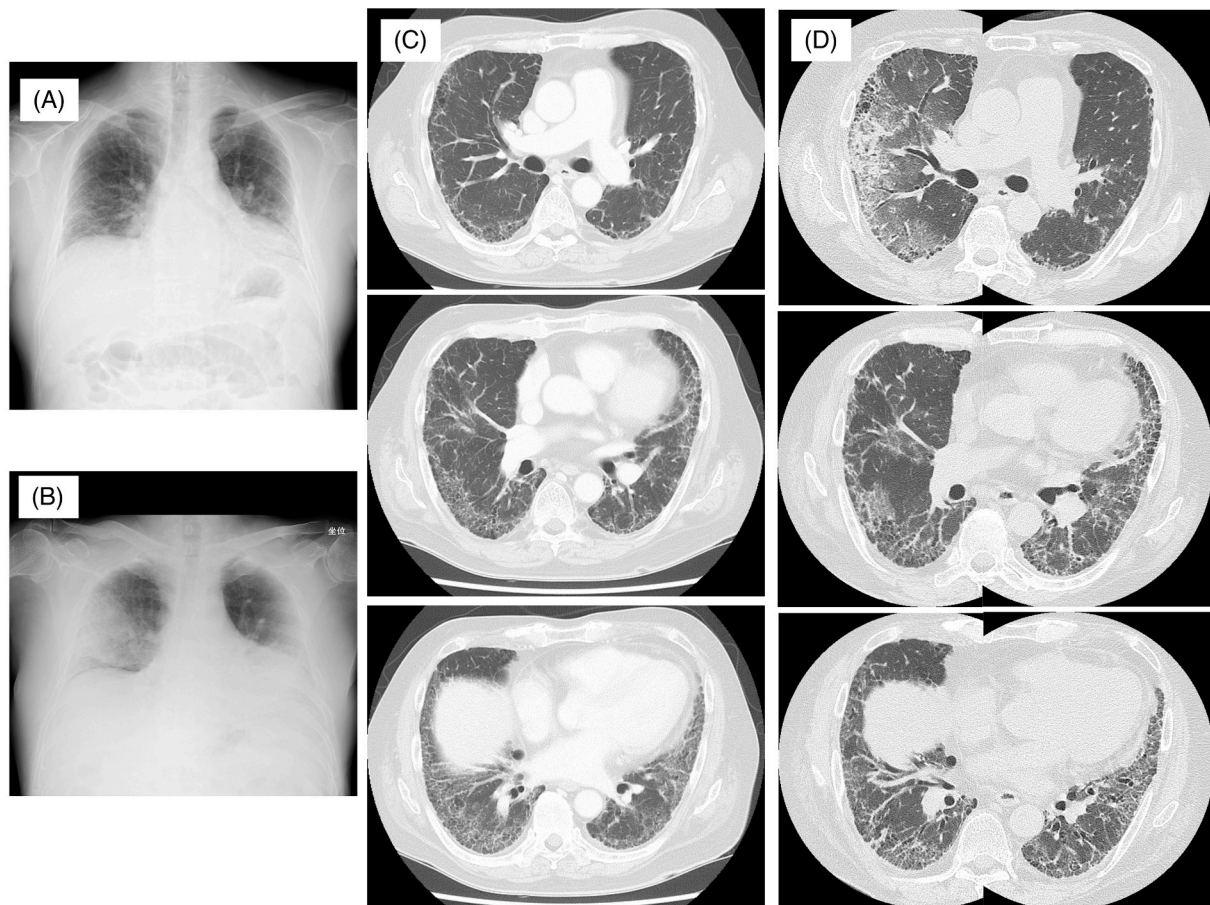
Radiographic images of case #2. Chest X-ray images of the patient (A) before and (B) at the diagnosis of acute exacerbation of interstitial lung disease. Chest CT images of the patient (C) before and (D) at the diagnosis of acute exacerbation of interstitial lung disease.
